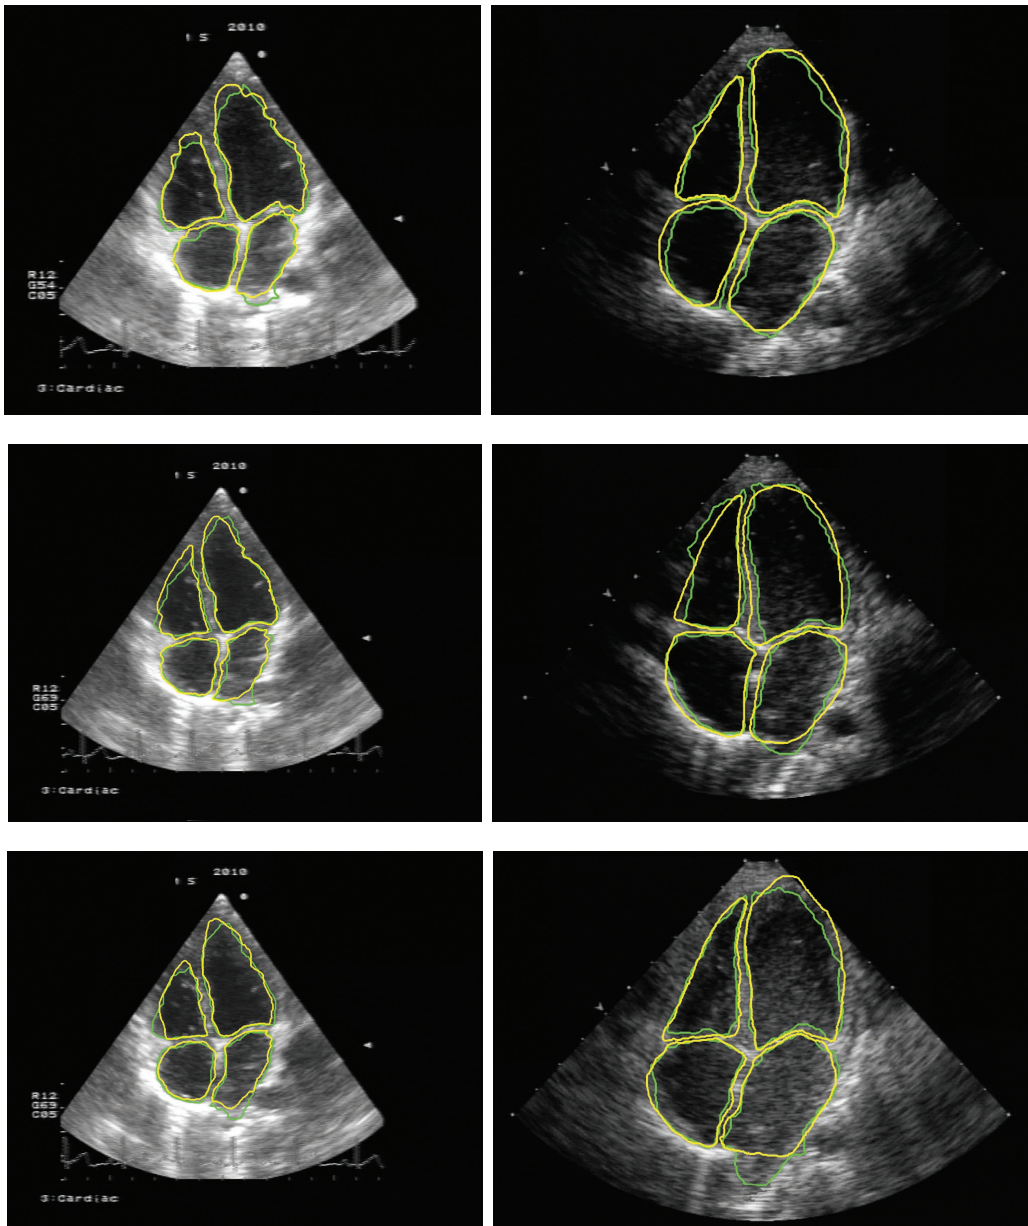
Examples of contours obtained using the proposed method (green) overlapped with contours manually drawn by physicians (yellow). The images on the left are from an echocardiographic equipment and the images on the right are from another standard equipment.
